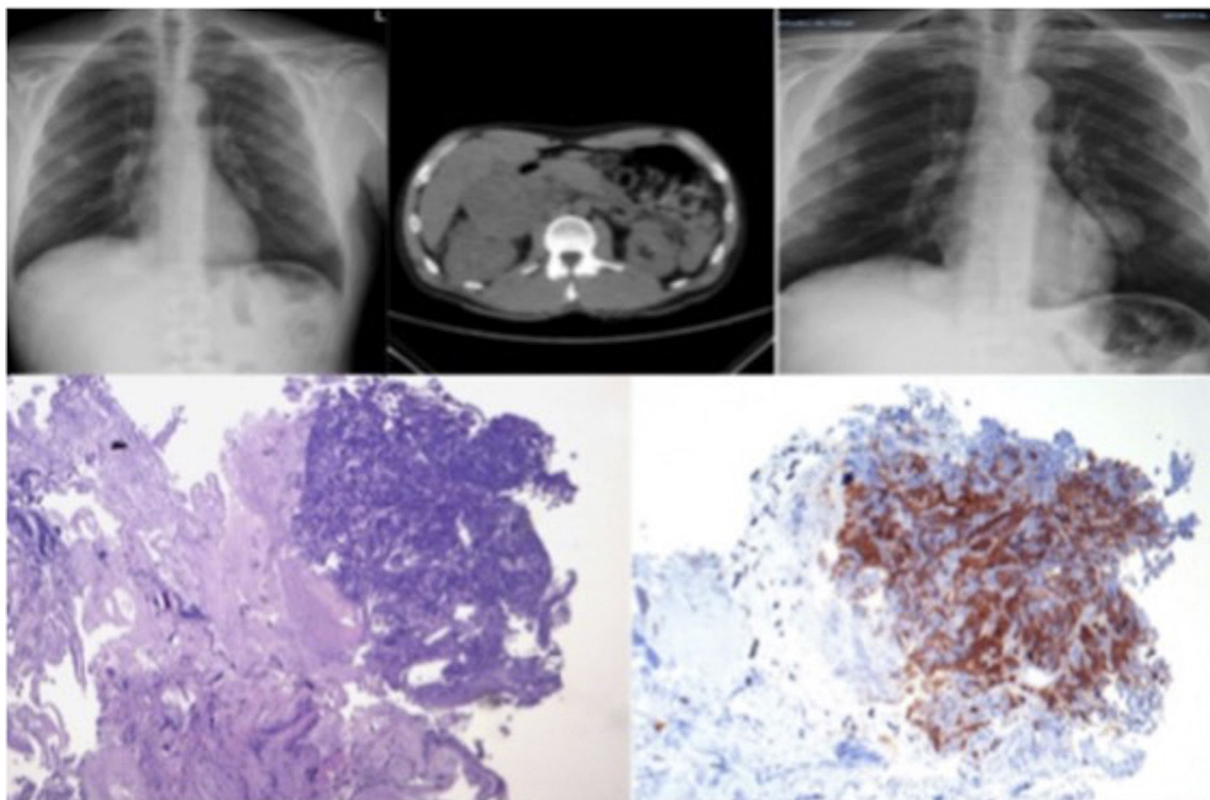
Top left, patient's chest X-ray; center, CT image showing adrenocortical mass; right, chest X-ray showing rapid progression of lung lesion; bottom row, pathology images of adrenocortical carcinoma, inhibin positive, and CK7, TTF-1 and napsin negative.
